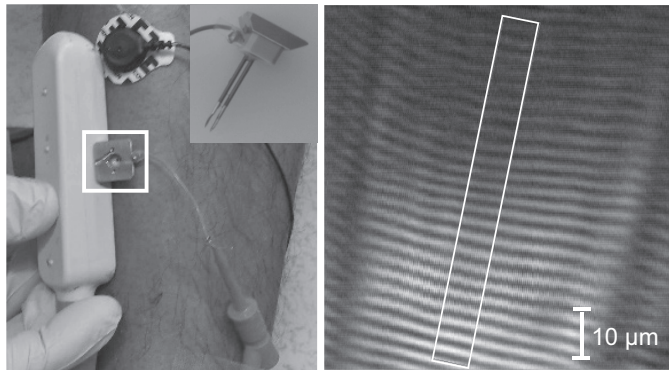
Experimental equipment and imaging setup. *Left*: needles (*inset*) were inserted in the muscle (center square), and ultrasound imaging was conducted parallel to this site. *Left inset*: image showing needle probe used in study, which includes two needles (emitter and collector). *Right*: images collected using the second harmonic generation imaging technique. White box indicates the region where the sarcomere length was calculated using Fourier analysis. Ripples at left and right of image indicate borders of muscle fiber with adjacent fibers.
